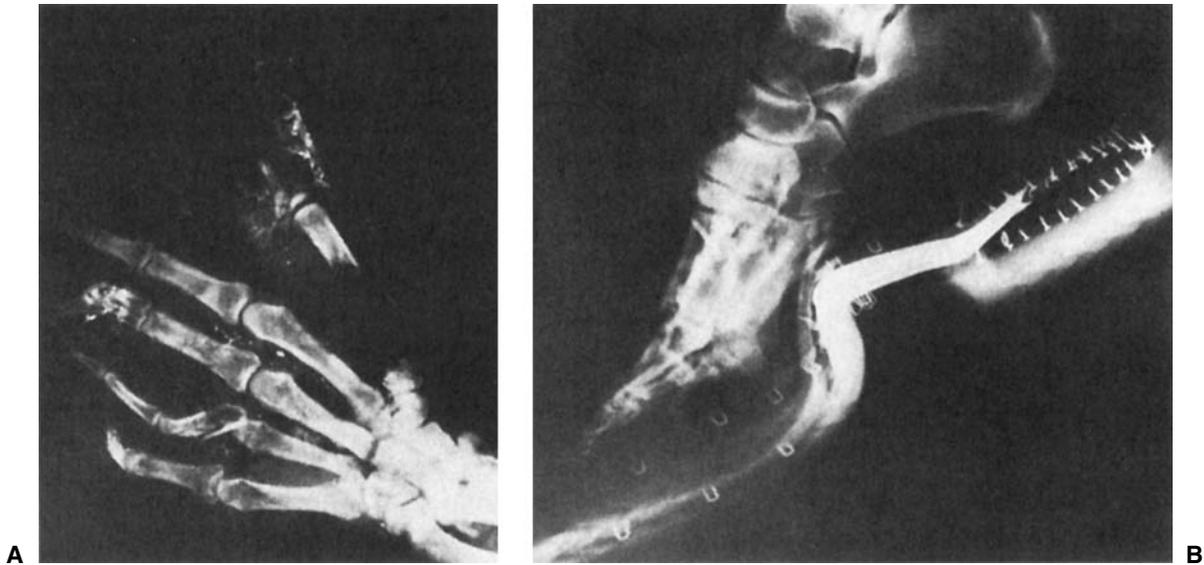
Radiograph of a hand (A) and foot (B) indicate that these were the extremities of the pilot, who was at the controls when this accident occurred (photo courtesy of Armed Forces Institute of Pathology).
